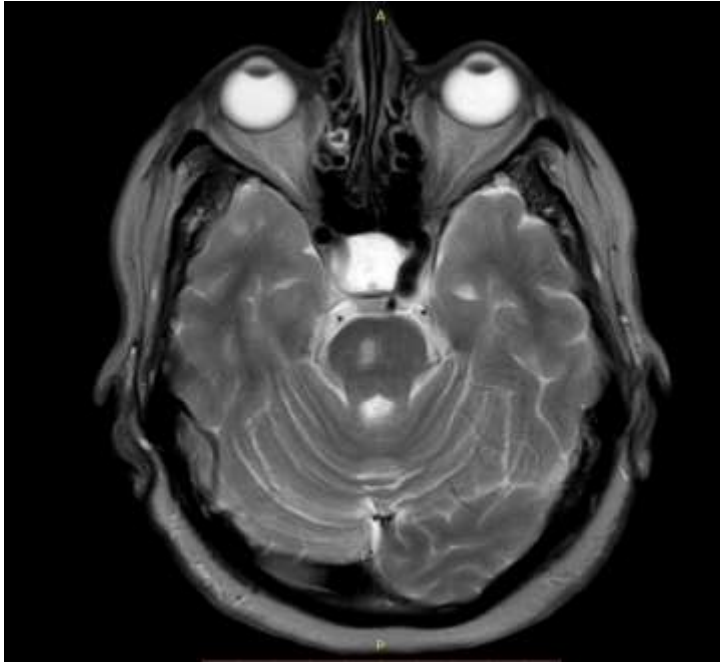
Axial MRI brain and cervical T2W-MV image for patient number 44 shows brain stem old infarction.
